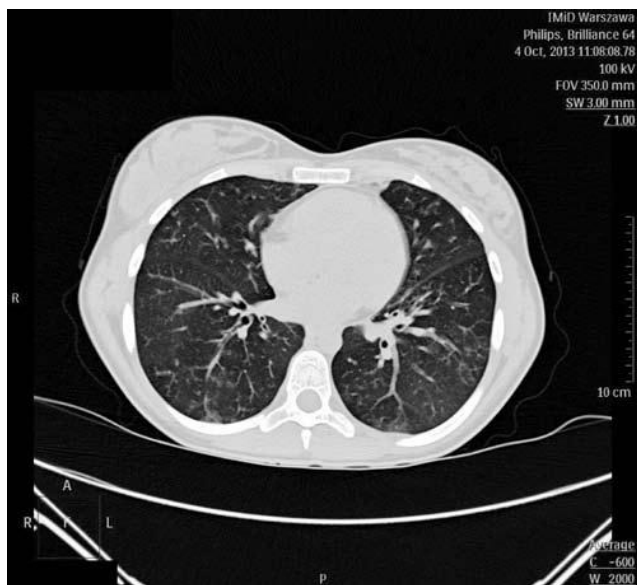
Chest CT scan of a 14-year-old girl with ABPA and CF shows ethereal infiltrates most severe in 6 segments of both lungs. (CT was performed in the Department of Diagnostic Imaging of the Institute of Mother and Child in Warsaw).
